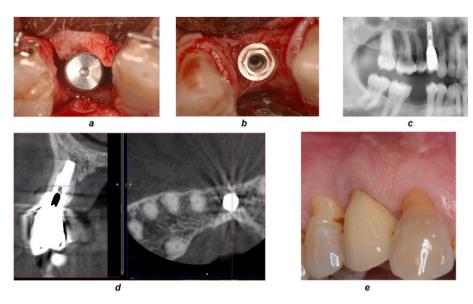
a, the overturning of the fractured bone with cortical site versus the implant site and bone marrow positioned on the vestibular site; b, occlusal view of implant site after 5 months from the surgical bone augmentation and immediate implant placement; c, orthopantomography after 18-years of follow-up with implant showing no sign of marginal bone loss; d, CBCT after 18-years of follow-up with implant site showing no sign of prosthetic rehabilitation after 18-years of follow-up, the peri-implant probing depth is of 1 mm, no changes from baseline.
